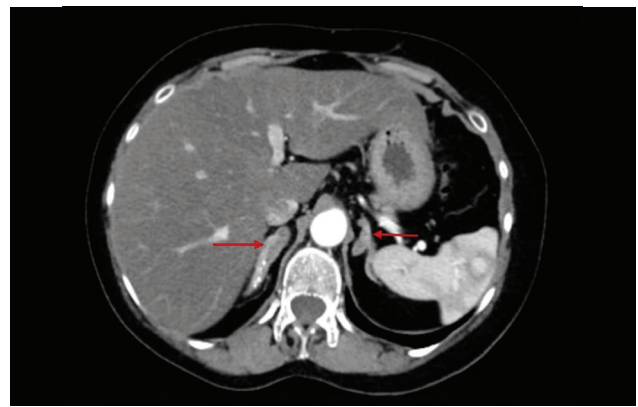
Contrast-enhanced computed tomography of the abdomen showing bilateral adrenal hyperplasia (red arrows).
